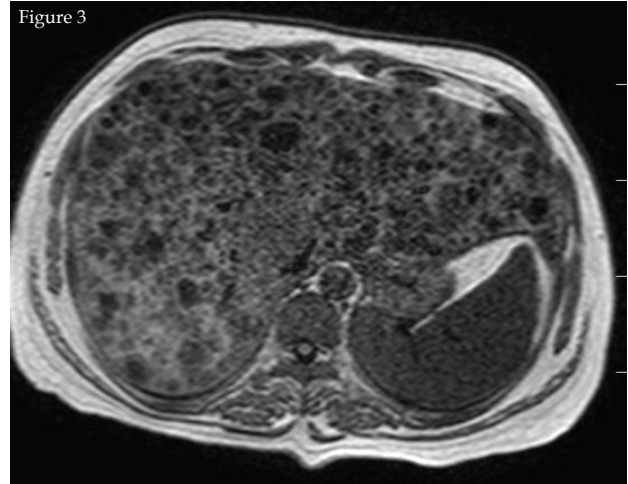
and 4 T1WI and T2WI on axial MRI showing well defined hypointense and hyperintense cysts respectively. Cysts were also indenting the intrahepatic IVC.
